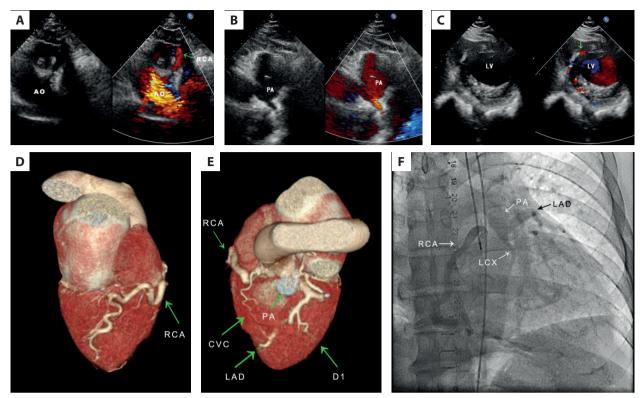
A. Transthoracic echocardiography revealed a dilated RCA originated from the Ao. B. Color Doppler showed abnormal blood flow directed towards the PA. C. Color Doppler revealed turbulent flow inside the interventricular septum. D. Volume-rendered 3D coronary computed tomography indicated a dilated RCA. E. The LCX originating from the pulmonary trunk and the collateral circulation between the left and right coronary arteries. F. The baseline coronary angiography revealed that the thick RCA supplied blood to the tortuous left coronary artery *via* collateral circulation, with the left coronary artery opening into the pulmonary sinus at the root of the pulmonary artery Abbreviations: Ao, ascending aorta; CVC, collateral vascular circulation; D1, diagonal branches 1; LAD, left anterior descending artery;
